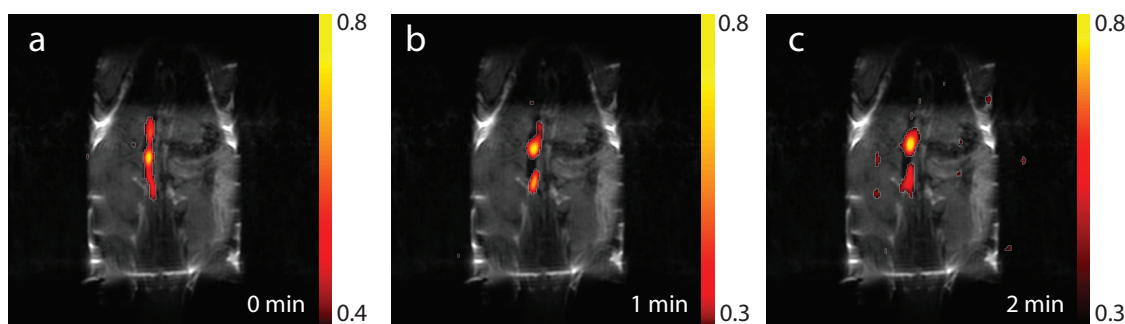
^{29}Si MRI of hyperpolarized silicon particles injected intravascularly via a tail vein catheter. The vena cava is visible immediately after injection. Images taken one minute and two minutes after the injection show particle accumulation in the portal veins and liver and spleen.
